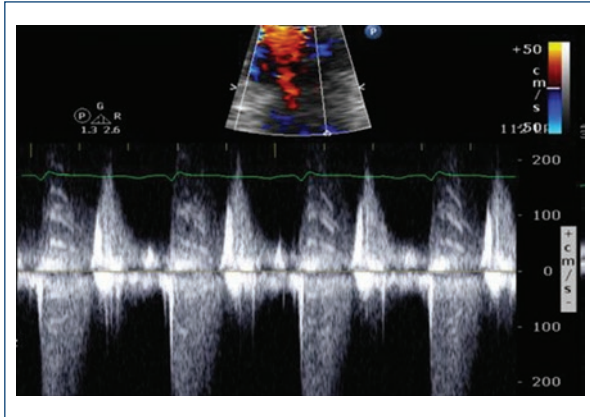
Transthoracic echocardiography showing continuous Doppler interrogation of the mitral regurgitant jet showing fragmentation on the Fourier Register.
